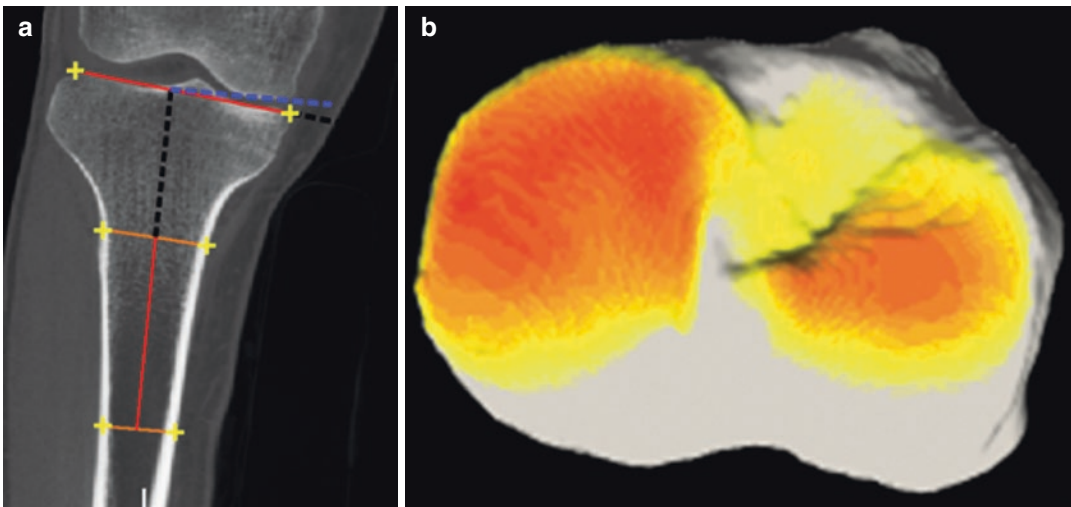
The emergence of specialized extremity CBCT systems motivates interest in development of anatomical measurements for quantitative assessment of joint alignment in 3D weight-bearing images. (a) A landmark-based
